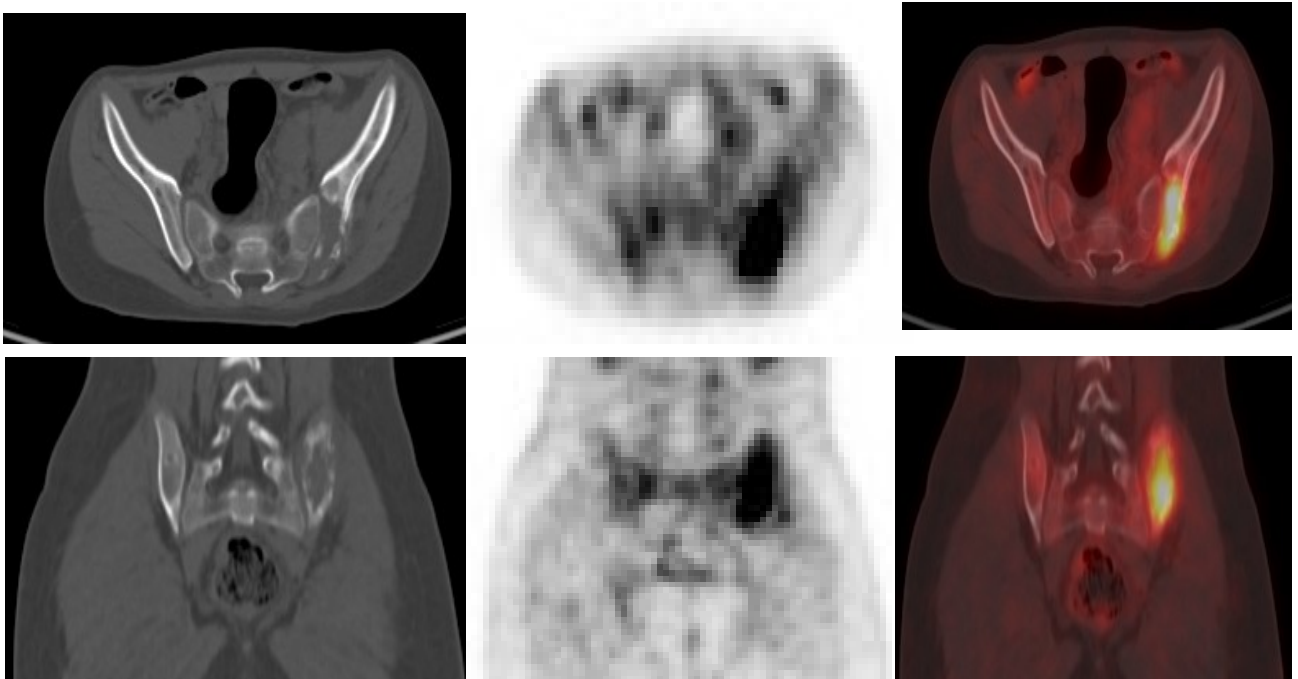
Initial pretreatment PET/CT revealed metabolically solitary active FDG avid destructive osseous lesion at the left iliac bone.
